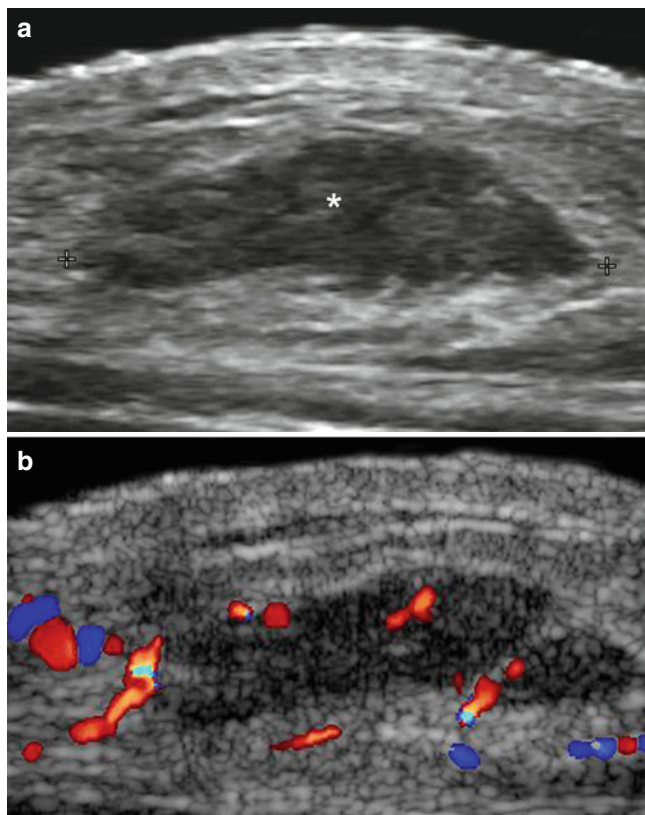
(a, b) Nodular fasciitis. (a) Grey scale ultrasound image (transverse view dorsal aspect of the right forearm) shows a well-defined oval-shaped mildly lobulated hypoechoic subcutaneous structure (*, between markers). (b) Color Doppler ultrasound image (transverse view) demonstrates increased vascularity within the muscle and the surrounding tissues
